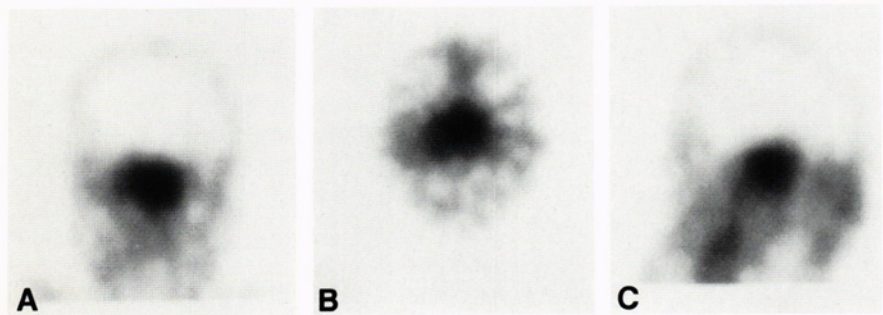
SPECT skull study presenting increased ^{67}Ga activity across the midline in (A) coronal; (B) transaxial; and (C) sagittal planes.
